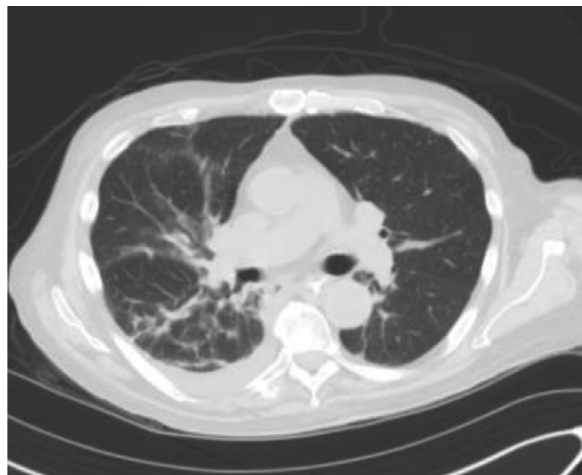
Chest computed tomography without intravenous contrast. Patchy ground-glass opacities with superimposed architectural distortion in the lung bases. Some mild fibrotic changes are thought to be related to COVID-19. COVID-19, coronavirus disease 2019.
